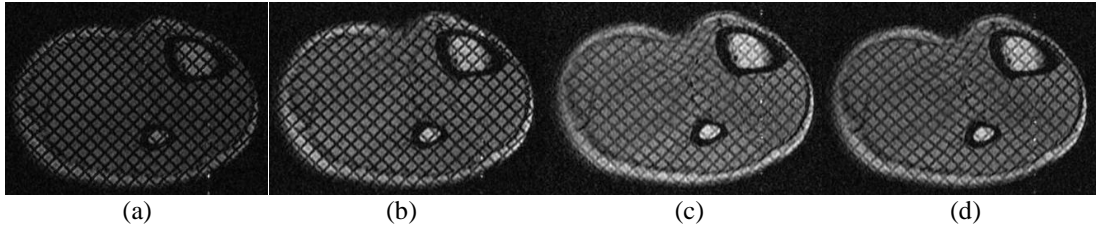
Tagged MR images of human lower leg. (a)-(d) Frame 1,3,5,7
